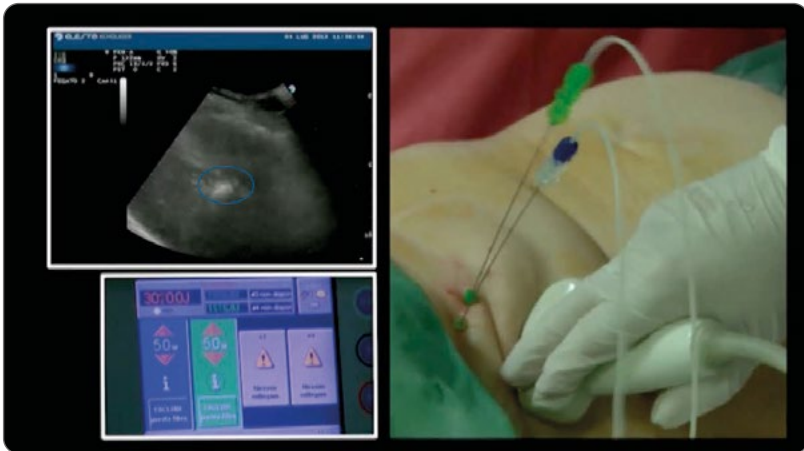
a) Hepatocellular nodule adjacent to the right kidney with extrahepatic growth in lesion (4.5-cm-diameter) was completely destroyed in a single session with four fibers, two pull-back and three applications. b) Post-treatment CT images show a large hypo attenuating coagulation zone.
